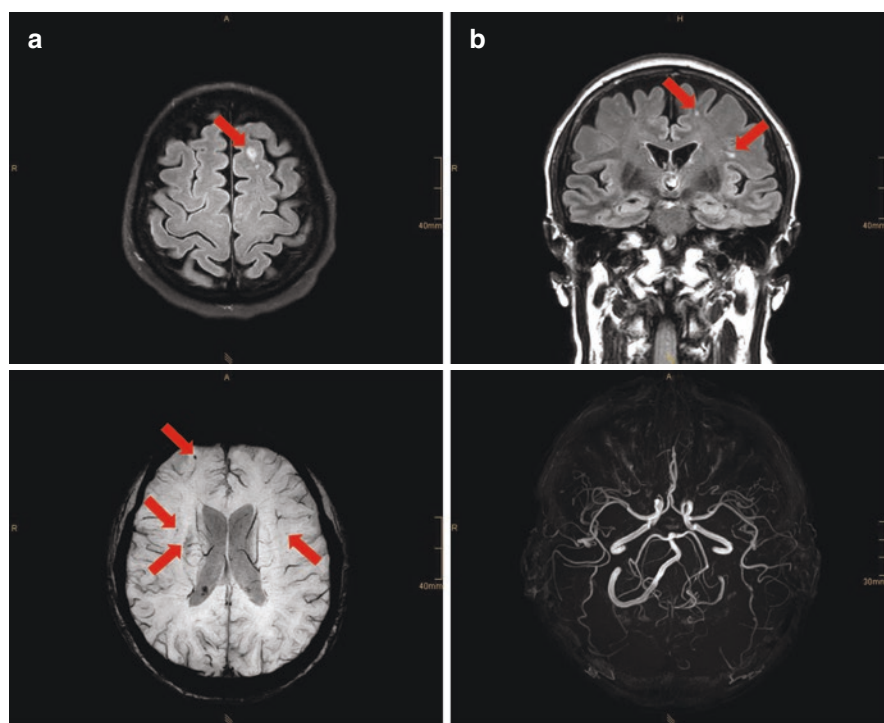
FSP case report [30]: Brain-MRI demonstrated signs of micro-angiopathy; several lacunar microinfarction zones (a, b), white matter hyper-intensities and micro-haemorrhages
